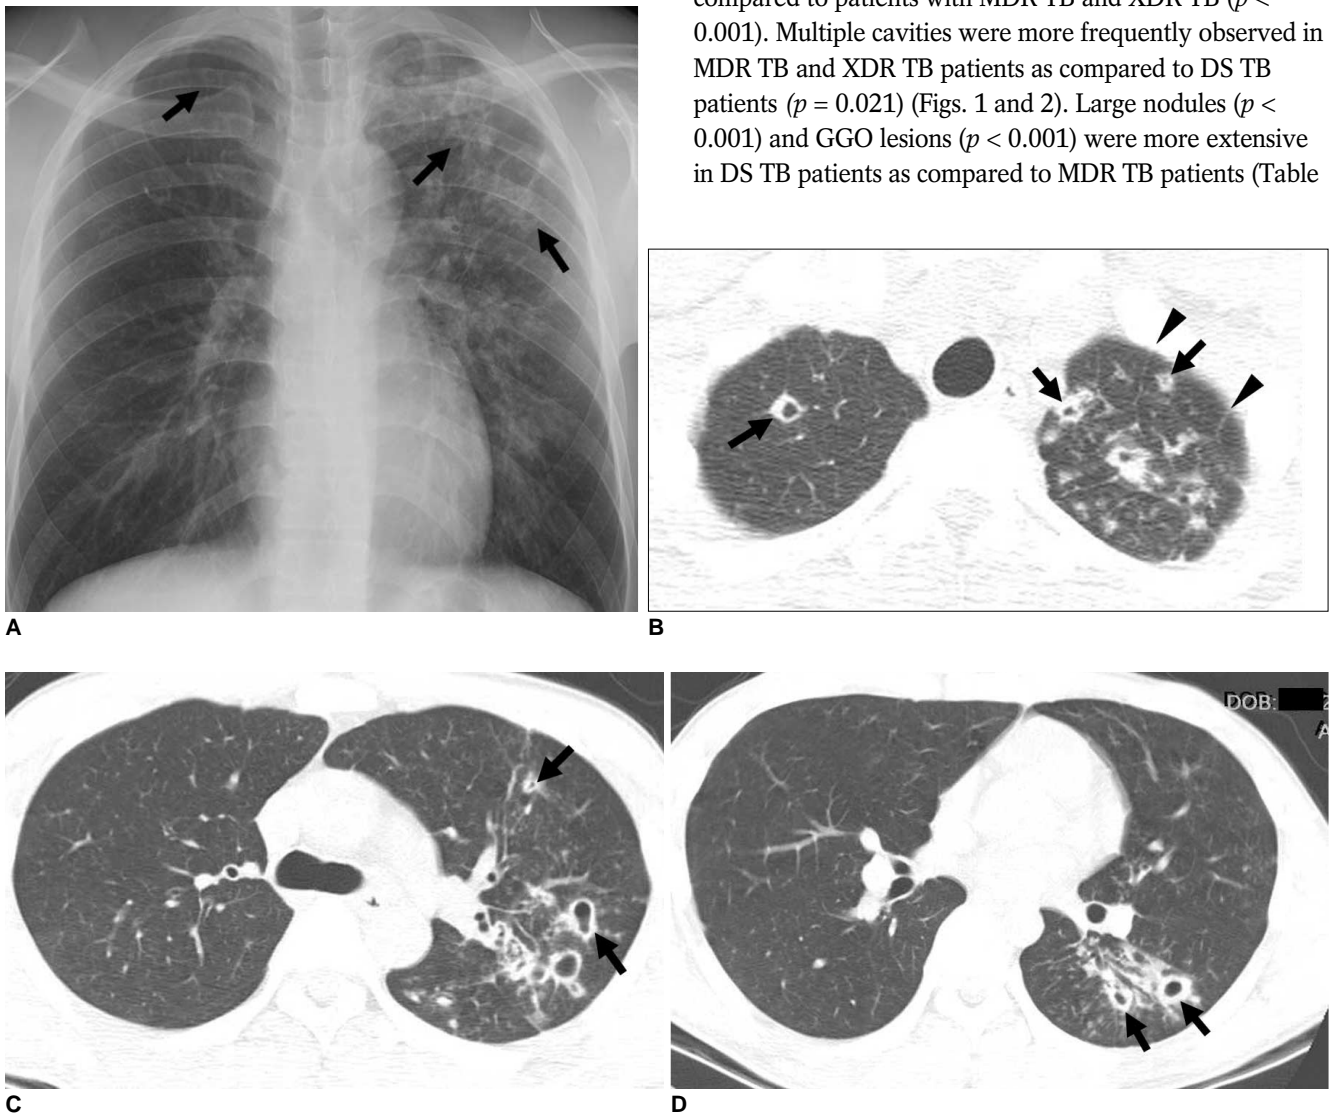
Findings for extensively drug-resistant pulmonary tuberculosis in 22-year-old man. A. Posterior-anterior chest radiograph shows small nodular lesions, reticulo-nodular lesions and cavitating nodules (arrows) mainly in left upper and middle lung zones and in right apex. B-D. Transverse CT (2.5-mm section thickness) scans obtained at levels of great vessels (B), main bronchi (C) and left basal trunk (D), respectively, show small nodules and cavitating nodules (arrows) mainly in left upper lobe and superior segment of left lower lobe. Also, note mild interlobular septal thickening (arrowheads) in left upper lobe.
